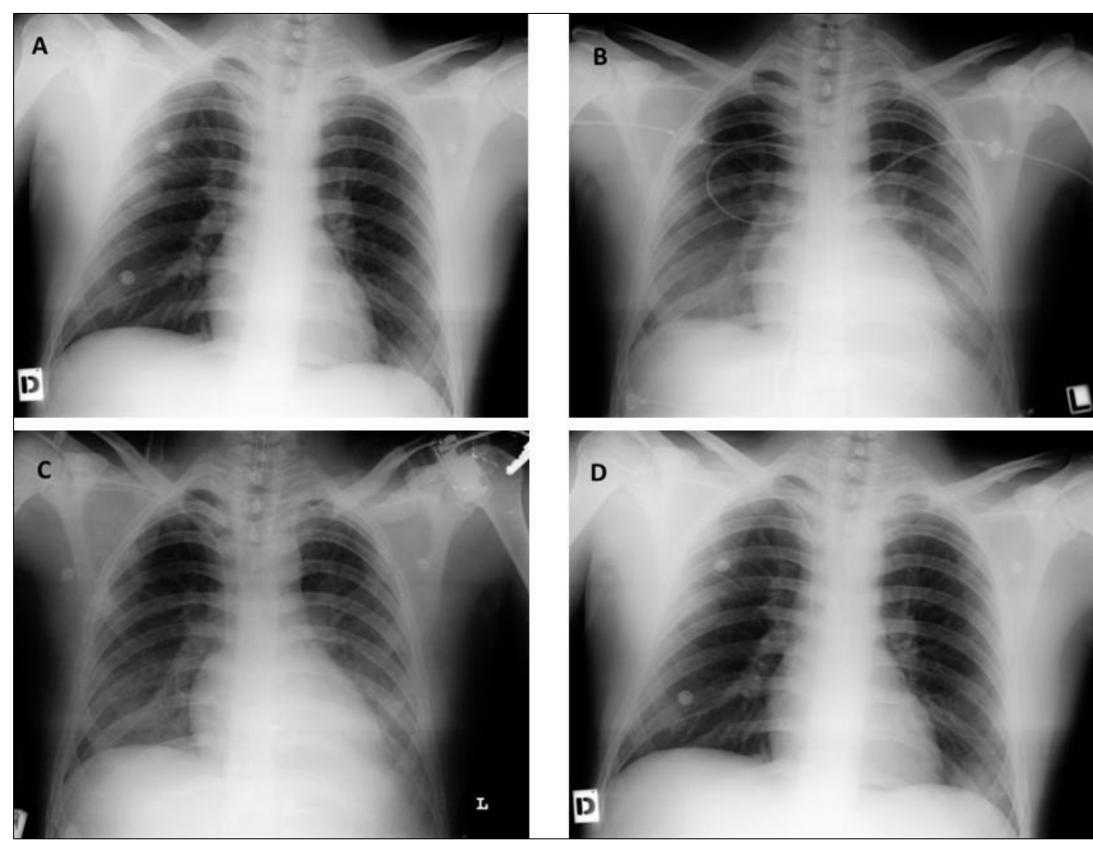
Chest x-ray in antibody-mediated TRALI due to HLA-II in Croatian patient in 2011: A - before transfusion (11/9/2011), B - bilateral pulmonary infiltrates after transfusion (15/9/2011), C - bilateral pulmonary infiltrates after intubation (17/9/2011), D - post-event significant radiological improvement (21/9/2011).
